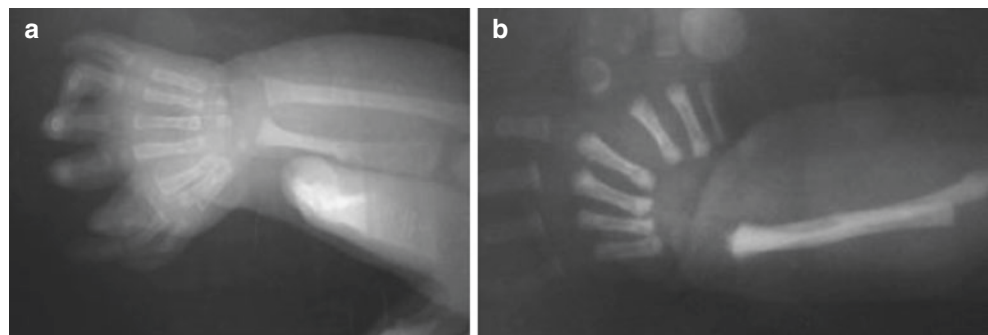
X-ray findings of left radial club hand
